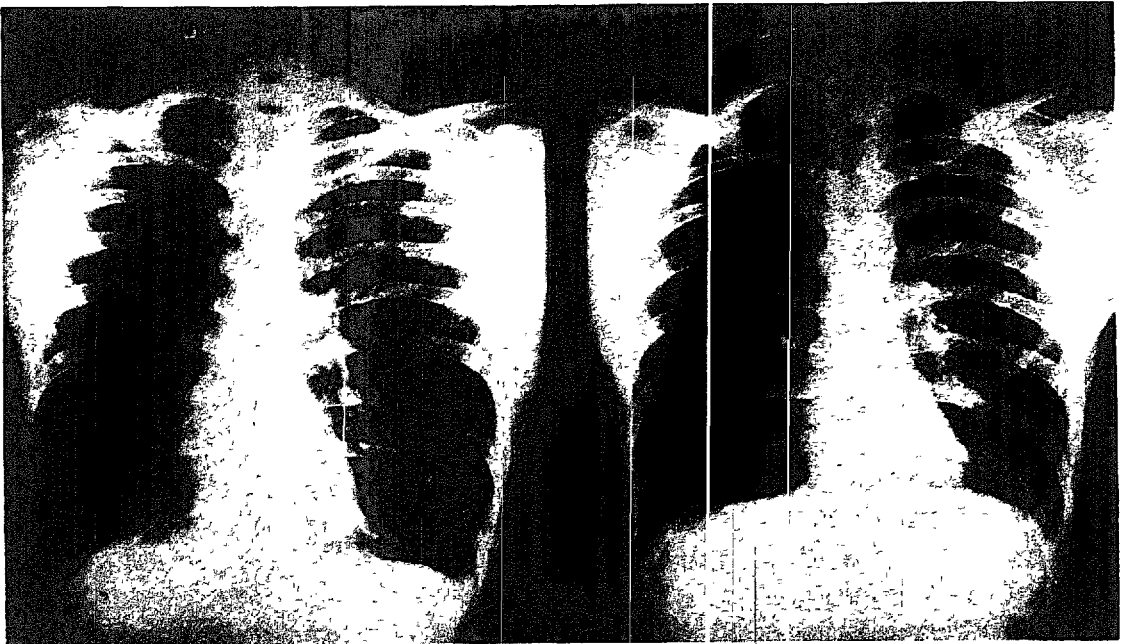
Inspiratory and expiratory X-ray (J-G A)
